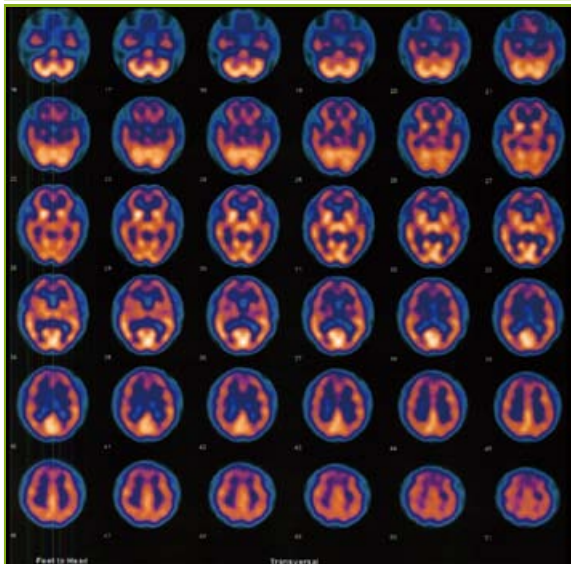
SPECT brain perfusion scan of Mr C conducted shortly after the negative CT brain scan, which again showed typical frontal-temporal perfusion deficits of FTD
